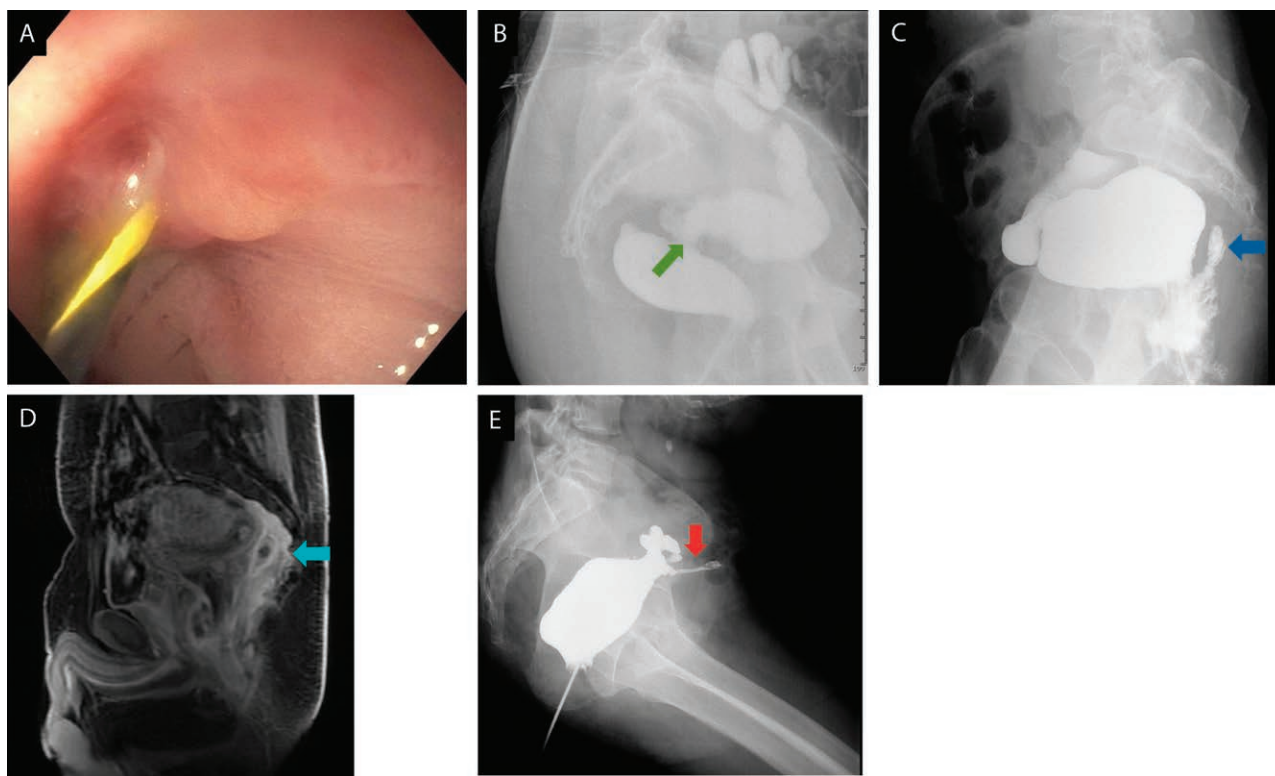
Endoscopic and imaging evaluation of pouch leaks and strictures. A, Detection of an anastomotic leak with endoscopic guide wire. B, Pouch-anal anastomotic stricture (green arrow) with a long cuff on gastrografin enema. C and D, Presacral sinus on gastrografin enema and MRI (blue arrows). E, A leak at the tip of the “J” leading to enterocutaneous fistula (red arrow) on gastrografin enema.
